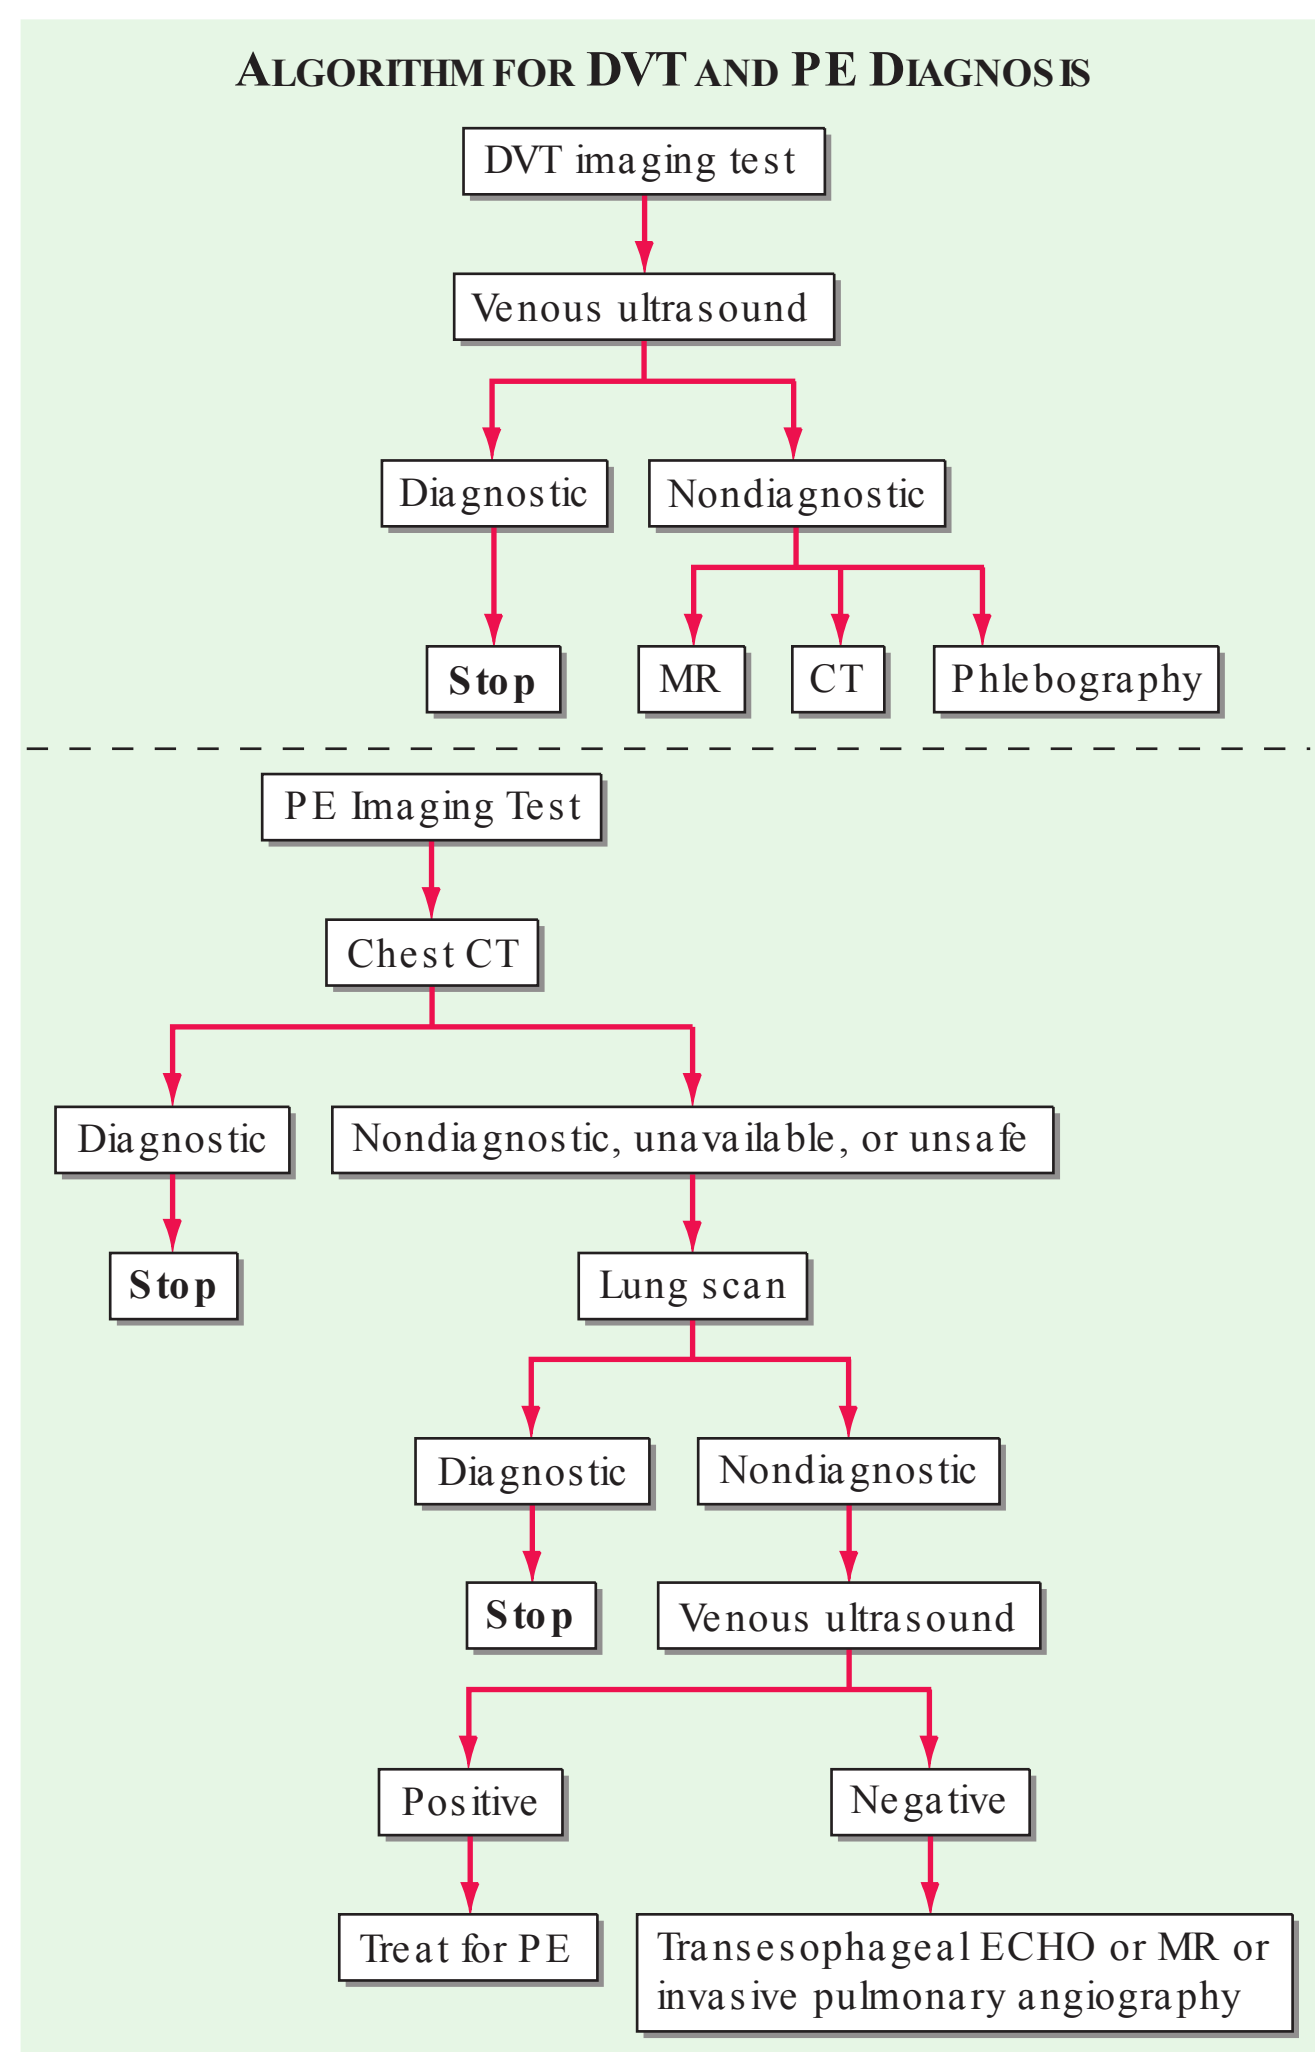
Imaging tests to diagnose DVT and PE. ECHO, echocardiography.
